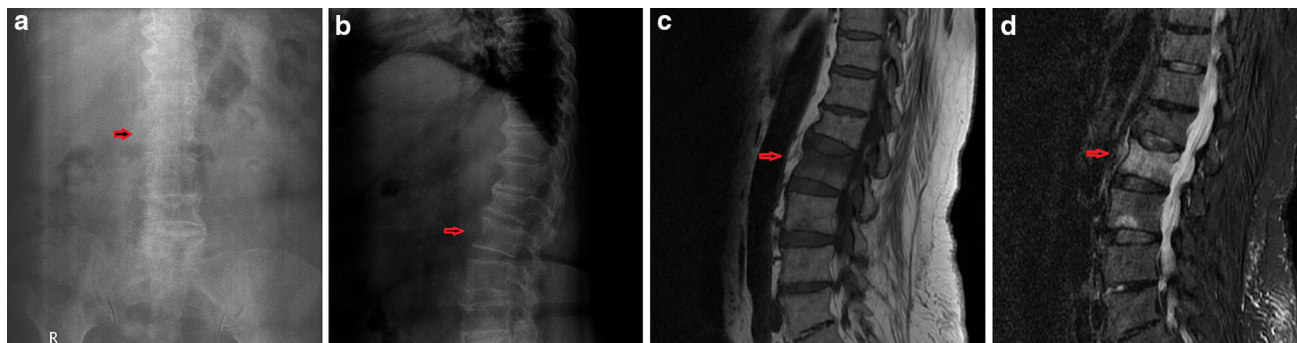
a–d Preoperative anteroposterior and lateral X-ray and T1-weighted and STIR-weighted MR images of the patients
